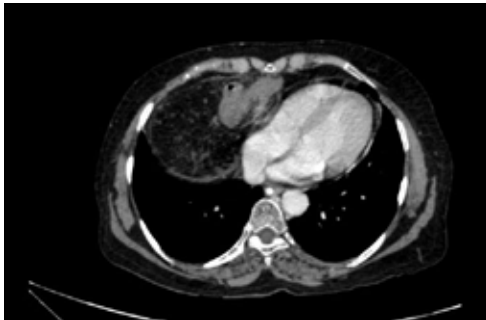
CT image showing retrosternal hernia with omentum and bowel as content.
